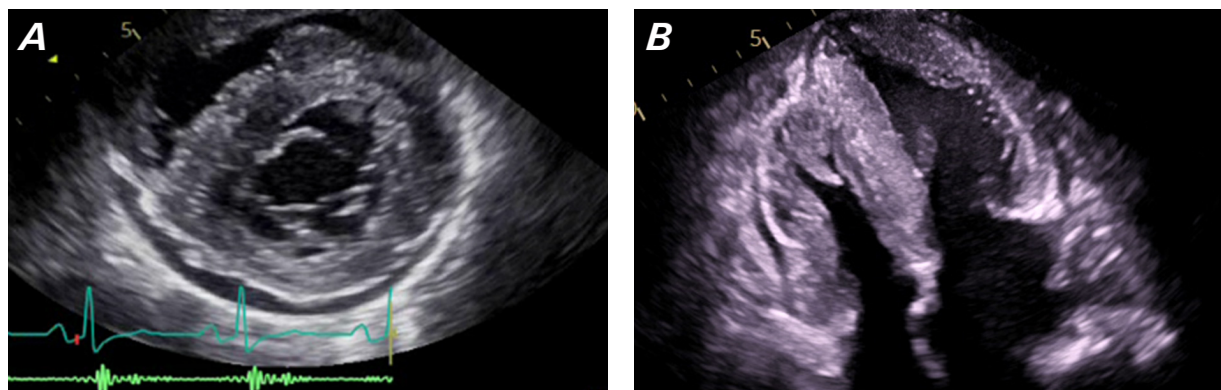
A) Parasternal short-axis (level of mitral valve) and B) apical 4-chamber views show prominent biventricular hypertrophy. Supplemental motion image for A also shows anterior motion of the mitral valve and narrowing of the right ventricular outflow tract during systole.
